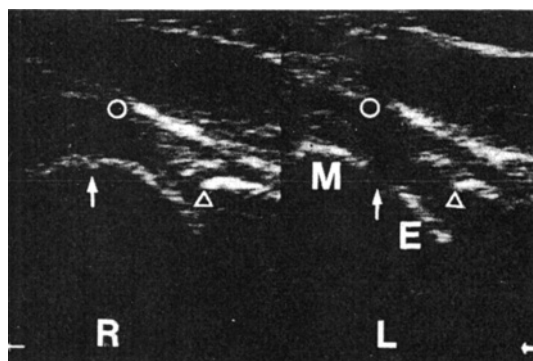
Lateral ultrasonograms of the same patient as in Figure 1. The lateral metaphysis (M), the epiphyseal plate (arrow), the lateral outline of the epiphysis (E), the lateral bony acetabular rim (triangle), and the joint capsule (circle) are visualized. The right hip (R) is normal, whereas the left hip (L) has a broadened epiphyseal plate and a mild physeal slip.
